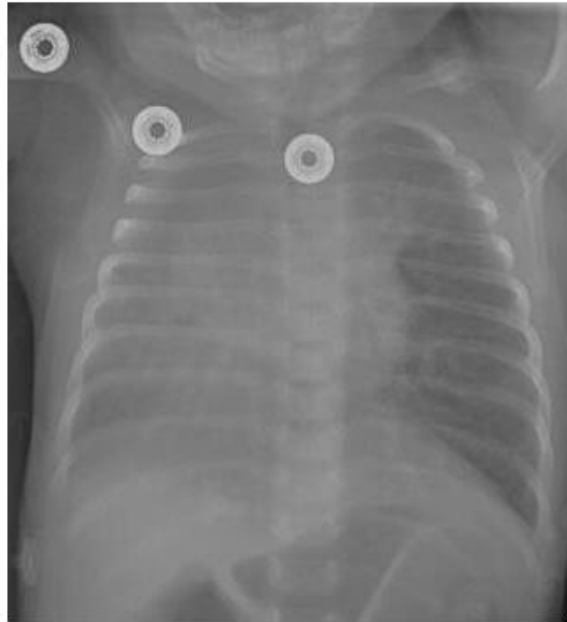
Chest X-ray of patient upon admission demonstrating diffuse right lung field opacification.
